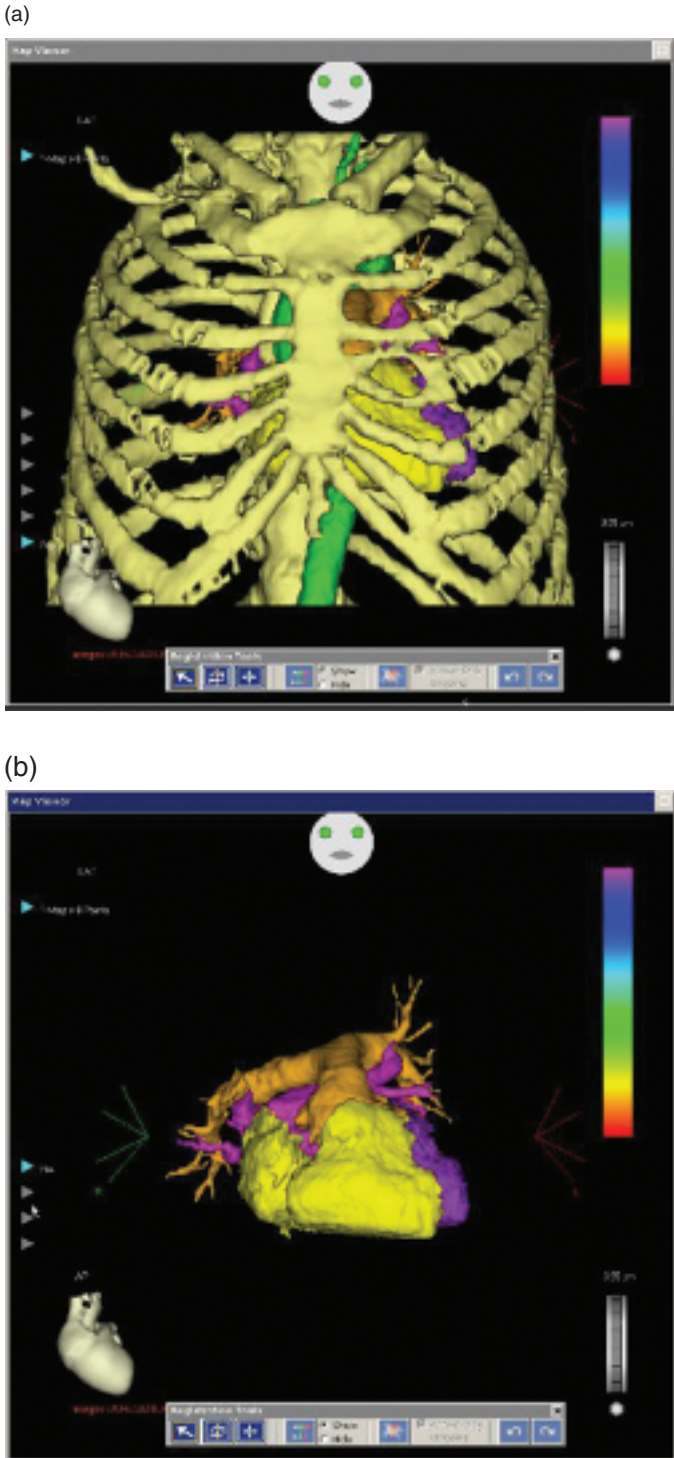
Three-dimensional reconstruction of a cardiovascular CT for electroanatomic mapping with image integration. (a) Three-dimensional image demonstrating all vascular and skeletal structures. (b) Editing of skeletal structures and aorta (green) with anterior view of pulmonary arteries (orange), right atrium and right ventricle (yellow), with the left atrium (purple). (c) Editing of pulmonary arteries. (d) Editing of right atrium and right ventricle. (e) Left atrium (posterior view).
